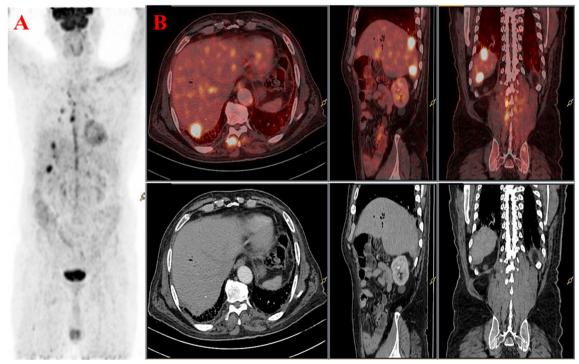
18F FDG PET/CT scan of a 76-year-old man was having right hypochondriac pain and pT2No stage and positive on PET/CT A, Maximum intensity projection image (MIP) shows abnormal foci of FDG avidity in thoracic and abdominal regions B, PET/CT and corresponding CT show FDG avid lesion in segment VII of liver
